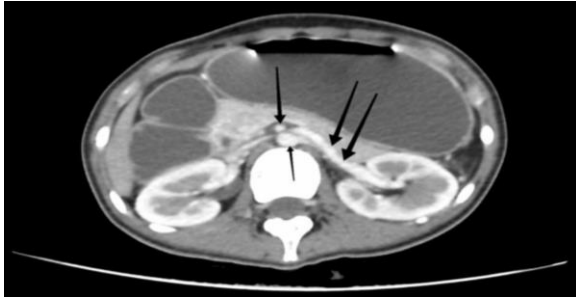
Axial view of CT scan Abdomen and Pelvis showing A short Aorto-mesenteric distance with SMA (long arrow) compressing the left renal vein which runs a tortuous and dilated course from the hilum of the left kidney (two arrows). Aorta is marked with a short arrow.
